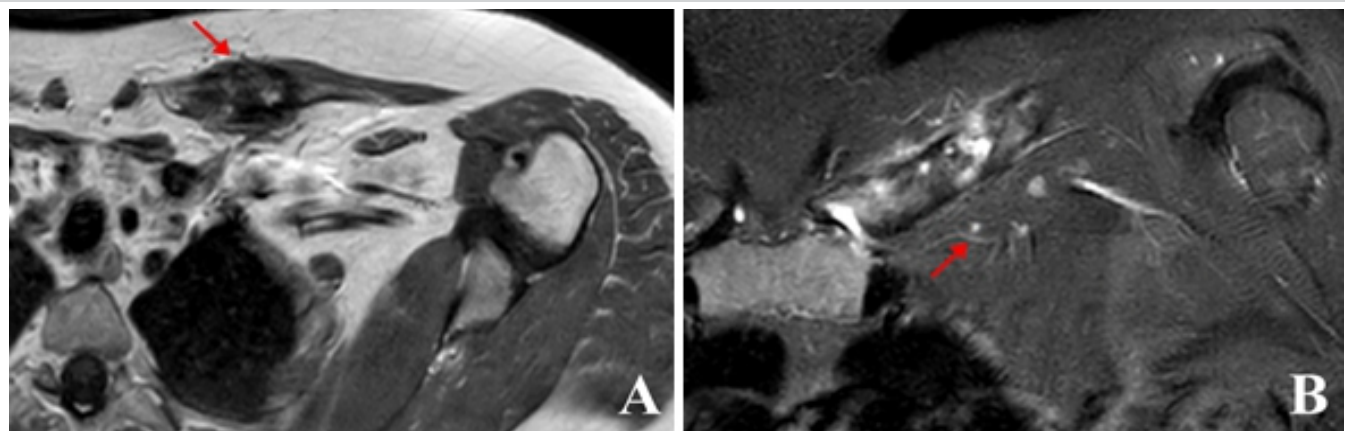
Magnetic resonance imaging with axial T1-weighted image (A) and coronal short tau inversion recovery (STIR) (B) of the left clavicle showing heterogeneous hypertrophic inflammatory bone remodeling (red arrow) with low signal on T1, high signal STIR.
